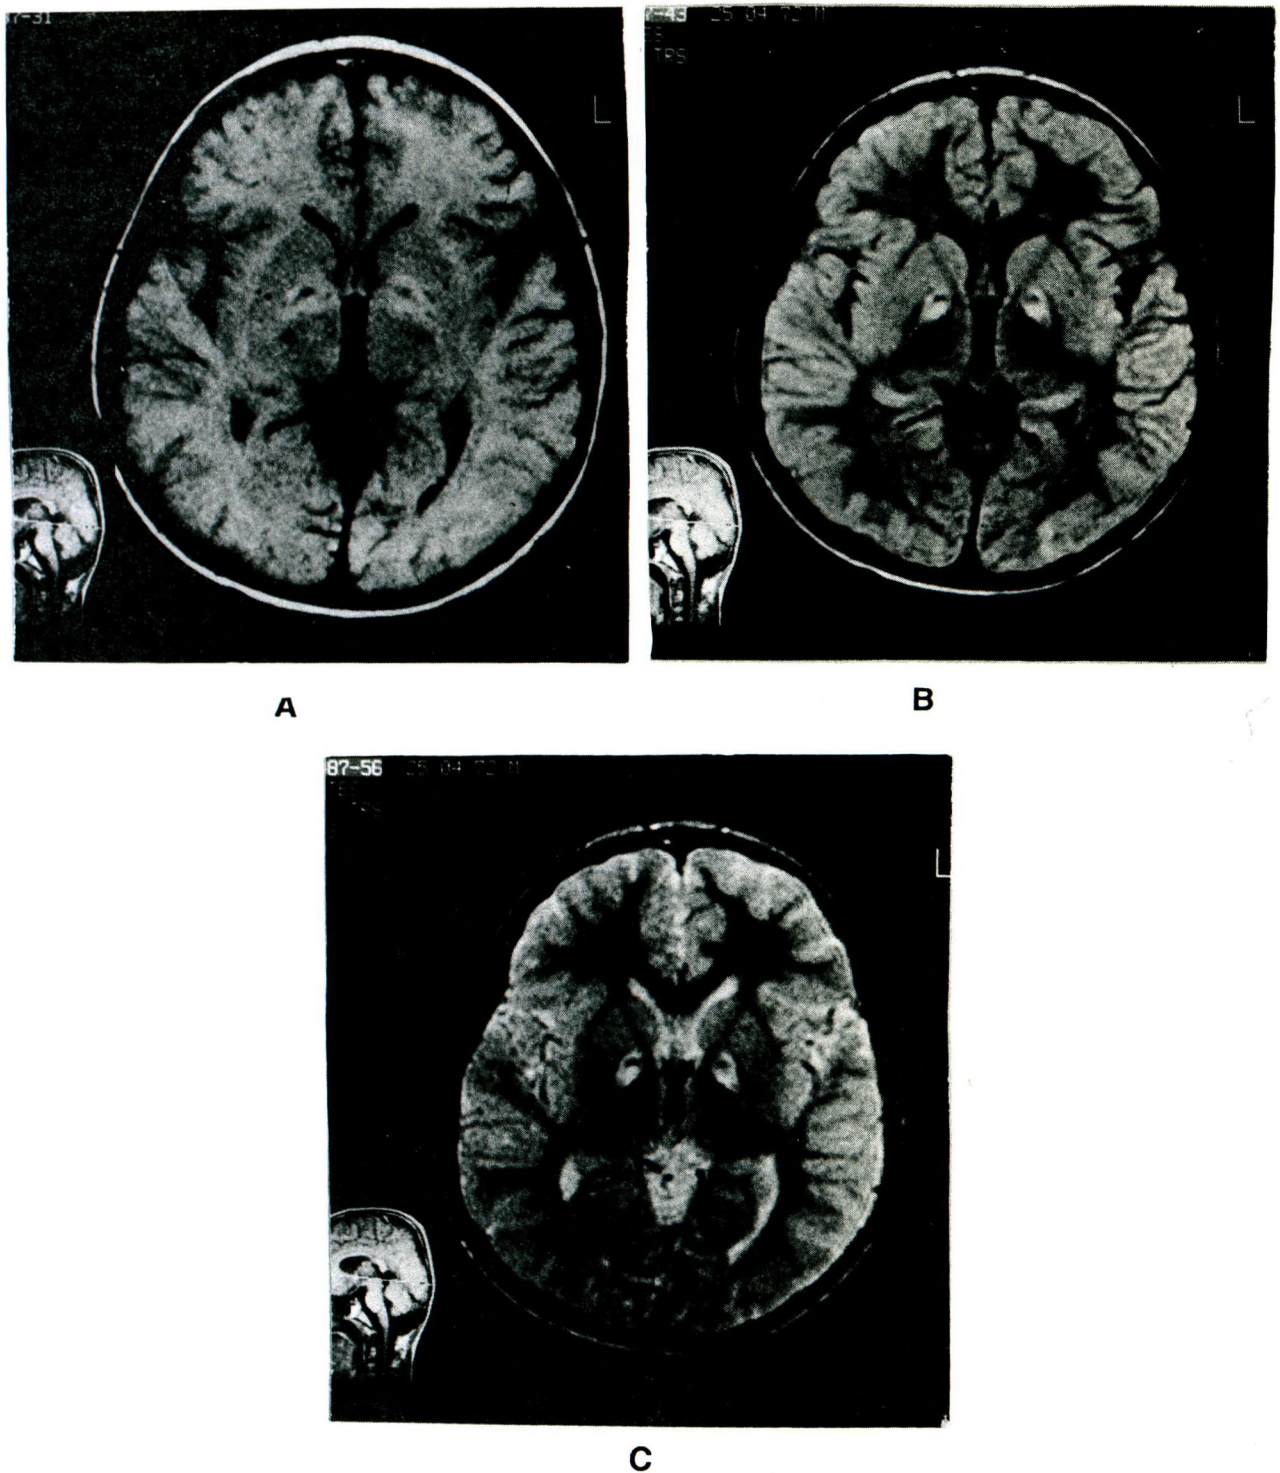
(A) T1-weighted axial MR image (TR=500 msec TE=38 msec) show decreased signal intensity in the globus pallidus (B) intermediate (TR=2100 msec TE=38 msec) (C) T2-weighted axial MR image (TR=2100 msec TE=110 msec) show the presence of both increased and decreased signal in the globus pallidus.
